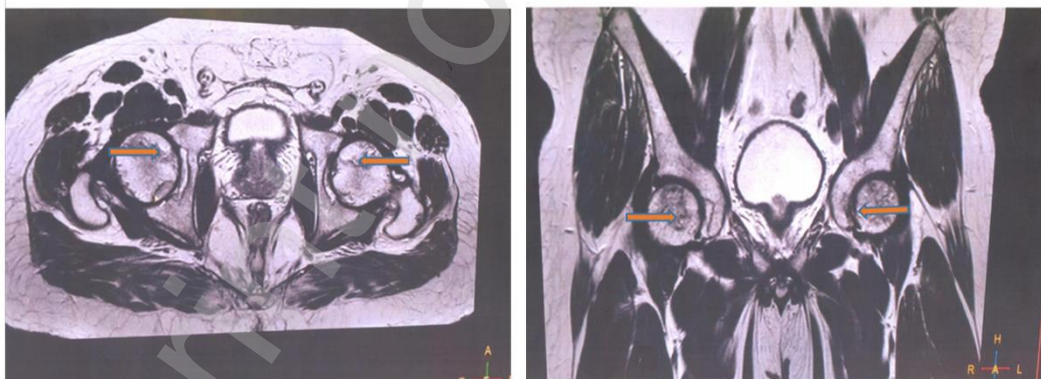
MRI and anteroposterior radiograph of the 49-year-old male patient confirming avascular necrosis of the femoral head of the bilateral hip (Ficat-Arlet-stage IIB).
